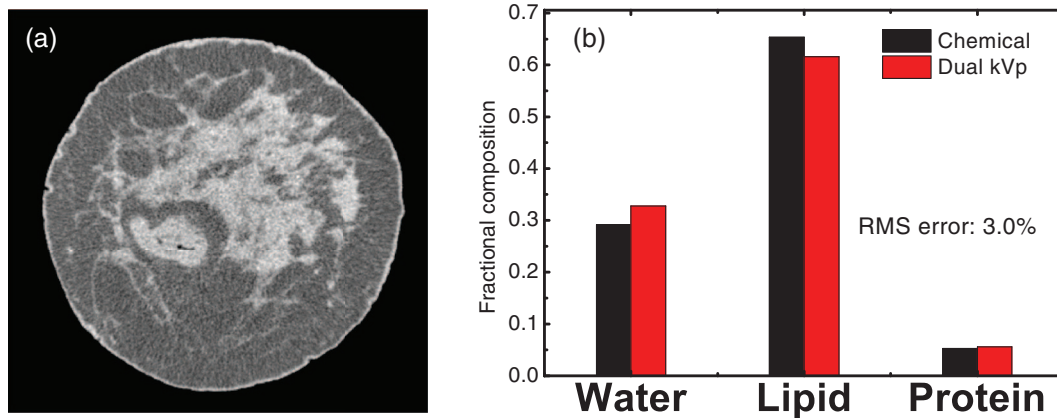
(a) A CT image reconstructed from low energy (50 kVp) scan for one postmortem breast sample. (b) Comparison of the composition measurements, in terms of water, lipid, and protein contents, between dual kVp CT and chemical analysis for the same sample. The RMS error for three-material decomposition is 3.0% for this sample.
